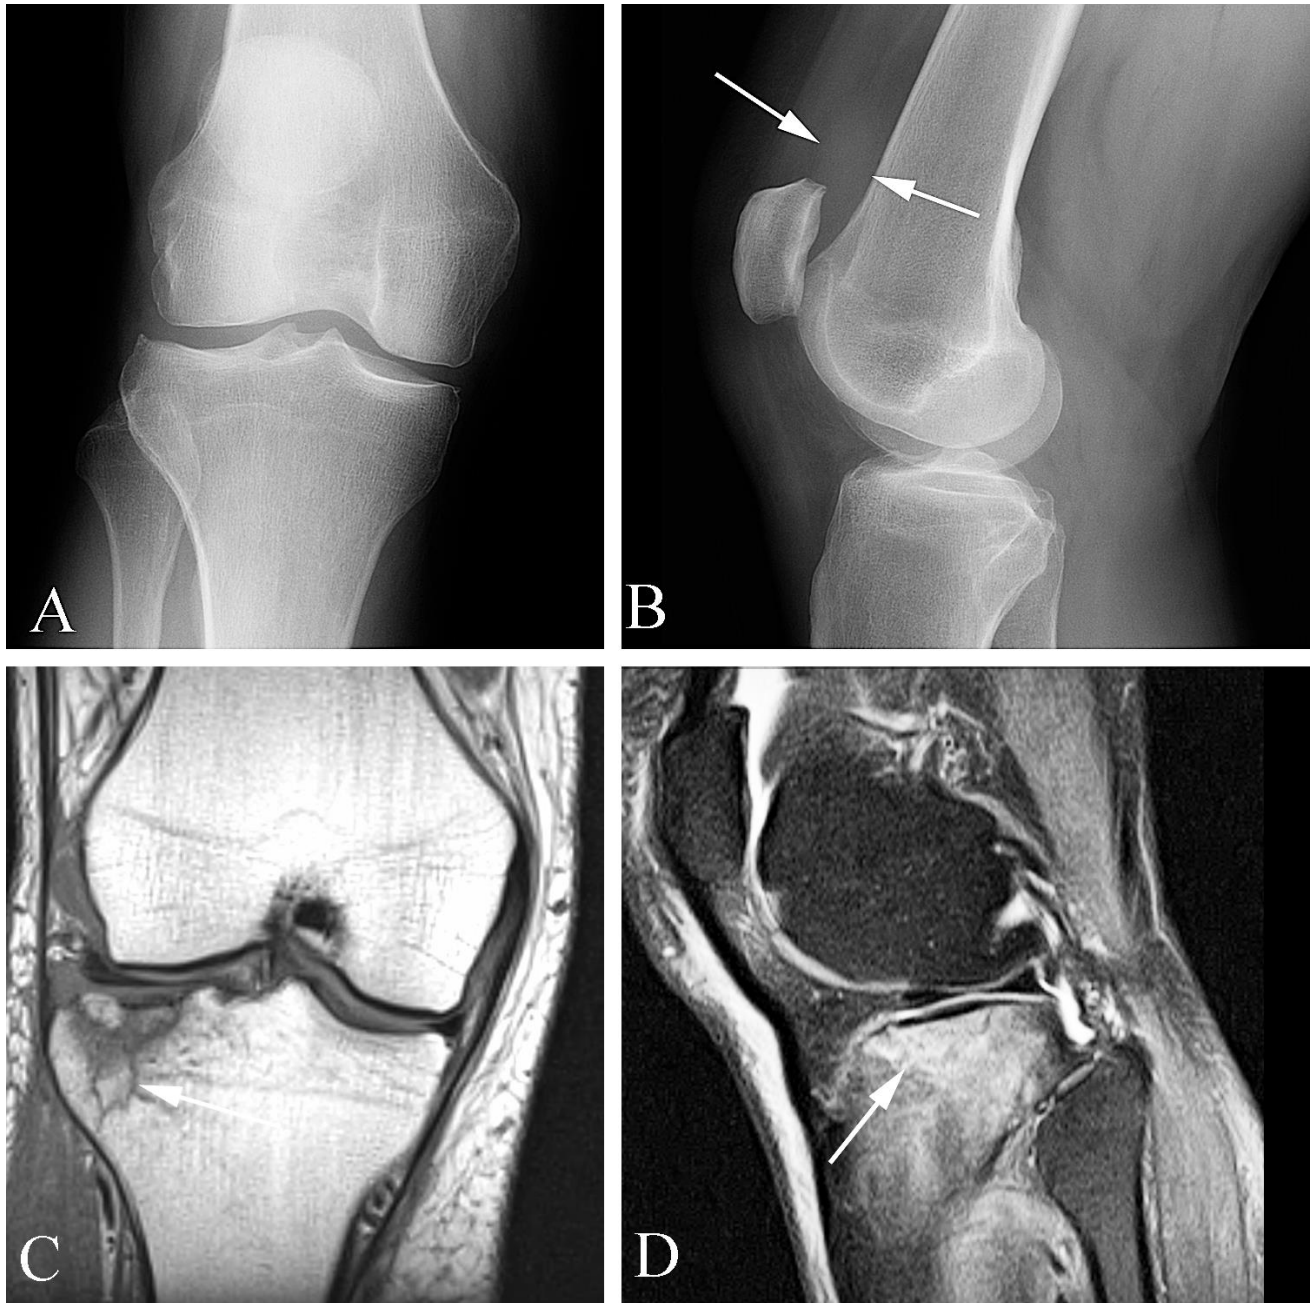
Radiographically occult fracture in a 62 year old man with pain following trauma. A. AP plain film of the knee shows no abnormality. B. Lateral plain film of the knee demonstrates fullness of the suprapatellar bursa (arrows), usually indicating a knee joint effusion. In the setting of acute trauma, this could indicate either a radiographically occult fracture, internal derangement (for example, a torn anterior cruciate ligament), or both. C. Coronal proton density MR image shows a combination of fracture (arrow) and contusion through the lateral tibial plateau. D. Sagittal fat-suppressed T2 weighted image demonstrates extensive increased signal intensity through the lateral tibial plateau (arrow) compatible with contusion.
